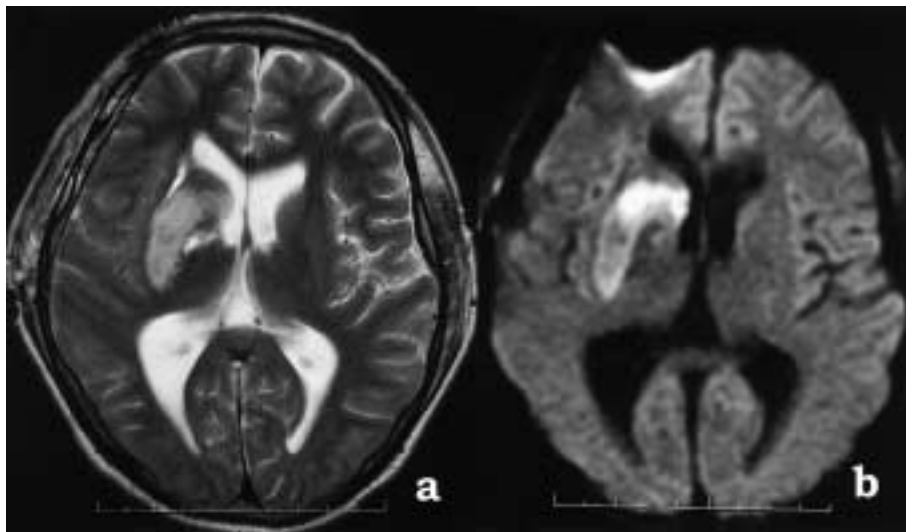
a MRI done after coiling procedure confirmed left basal ganglion ischemia. b Diffusion MRI also shows left basal ganglion ischemia.
